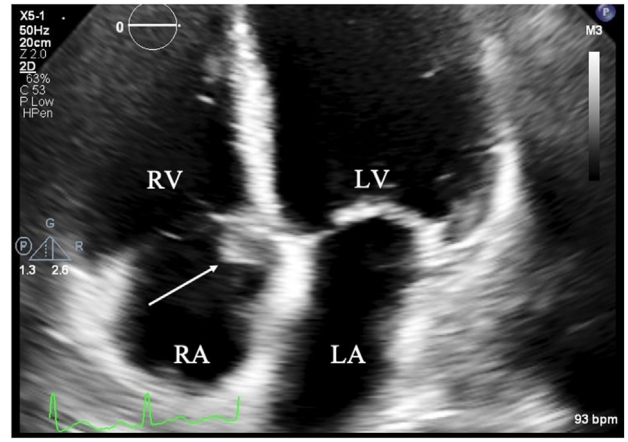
Two-dimensional TTE, apical 4-chamber cropped view, systolic phase, demonstrates a right atrial mass near the medial tricuspid annulus (arrow). LA, Left atrium; RV, right ventricle.
